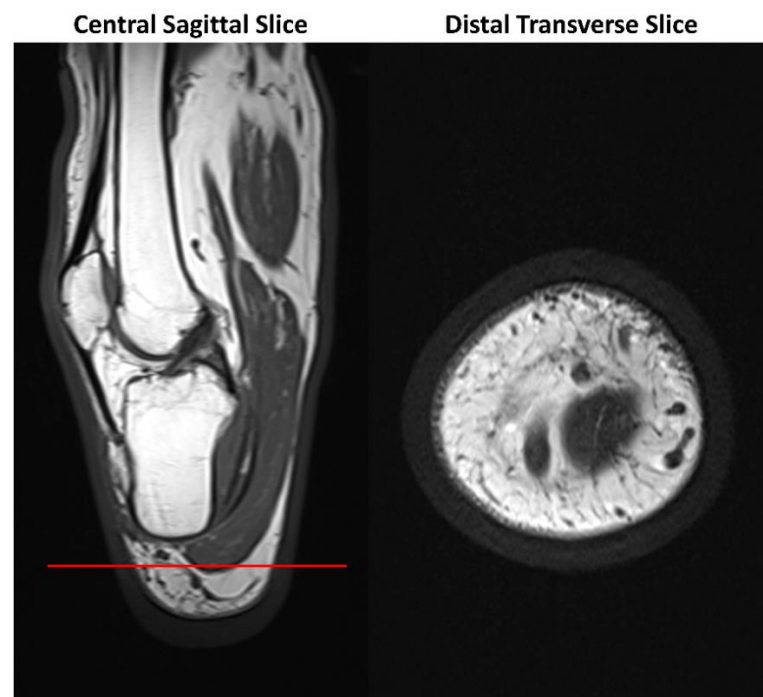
Left: central sagittal, and Right: distal transverse MRI slice of the residual limb of a male participant with unilateral transtibial amputation collected for Eurostars ImpAmp project [121]. Note: red line shows the position of the distal transverse slice
